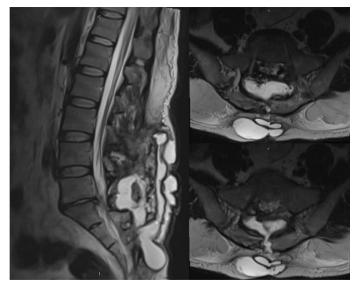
Sagittal and axial T2-weighted lumbar magnetic resonance images of the fifth patient revealed a giant lumbosacral iatrogenic pseudomeningocele
